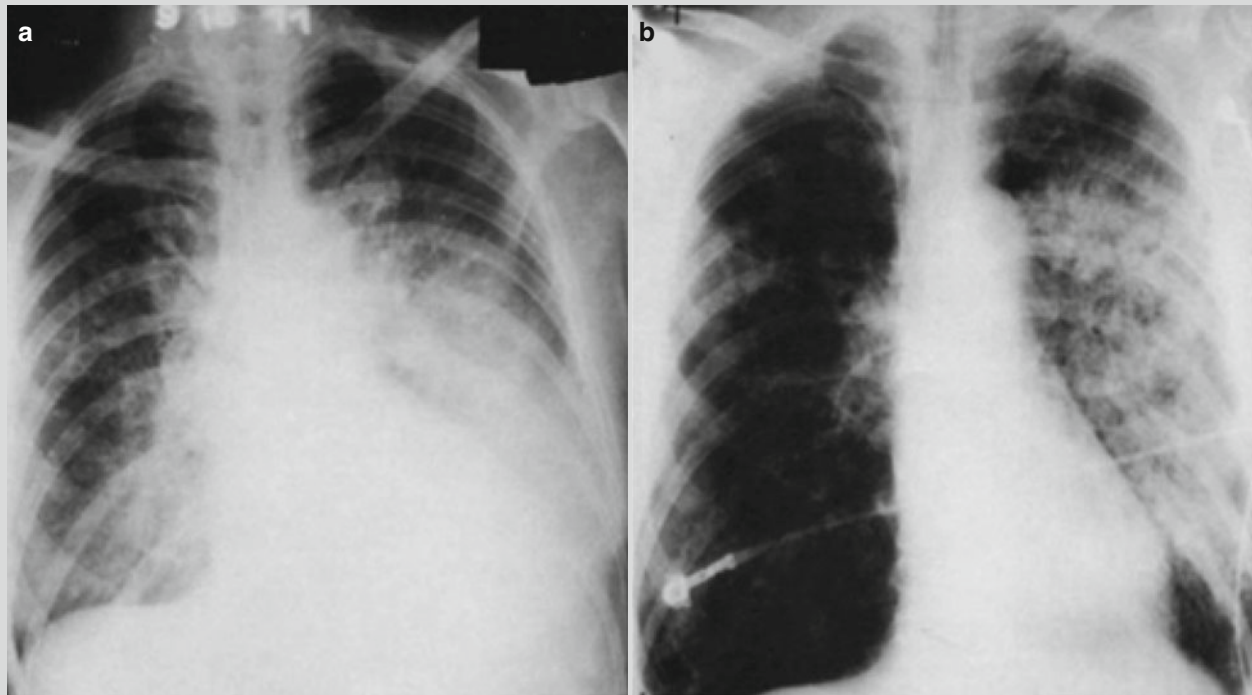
Legionella pneumonia. (a) At day 4 after the onset, chest X-ray demonstrates congestive heart failure. (b) At day 9 after the onset, chest X-ray demonstrates obvious flakes of shadows in the left lung after treatment for congestive heart failure.
